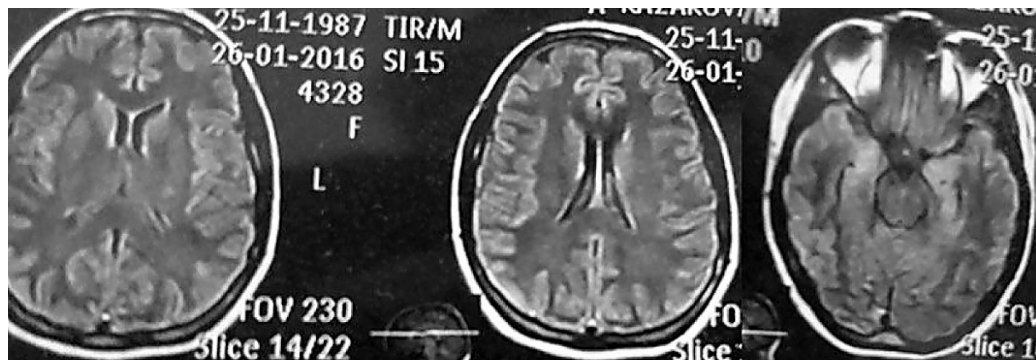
MRI image, FLAIR regime. Increased signal intensity from the mediobasal parts of the temporal cortex.
